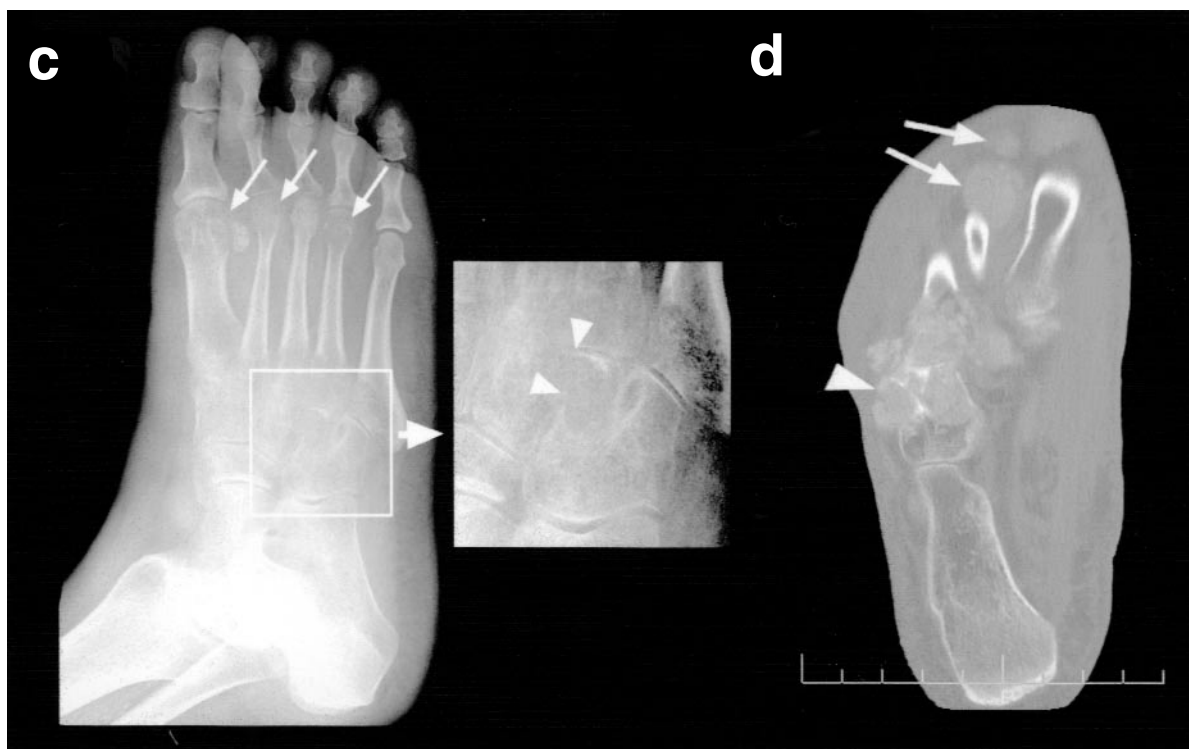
Lateral (a) and oblique (c) plain radiographs and reconstructed sagittal (b) and direct axial (d) CT of the right foot. These images reveal a homogeneous, high attenuation, soft tissue opacity in the dorsal soft tissues of the midfoot (a and b, white arrows) associated with scalloped erosion of the dorsum of navicular and medial cuneiform (b, black arrow). Similar, but smaller, opacities around the first to fourth metatarsophalangeal joints and the cuboid and cuneiforms (d, white arrows and arrowheads) are associated with more marked erosions (a, black arrow; c, white arrows). These erosions are juxtaarticular, with sclerotic margins and overhanging edges (c and d, arrowheads) typical of tophaceous gout.
